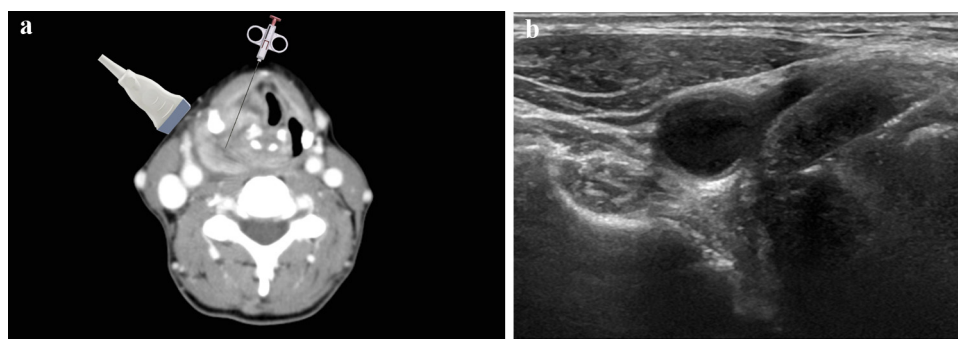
A 44 years-old woman with an untreated SCC in the hypopharyngeal region. (a) Axial contrast-enhanced CT shows a mass in the right piriform sinus. (b) USGTCB is performed introducing the needle through the free edge of the thyroid cartilage. Note: the probe and the needle are superimposed.
